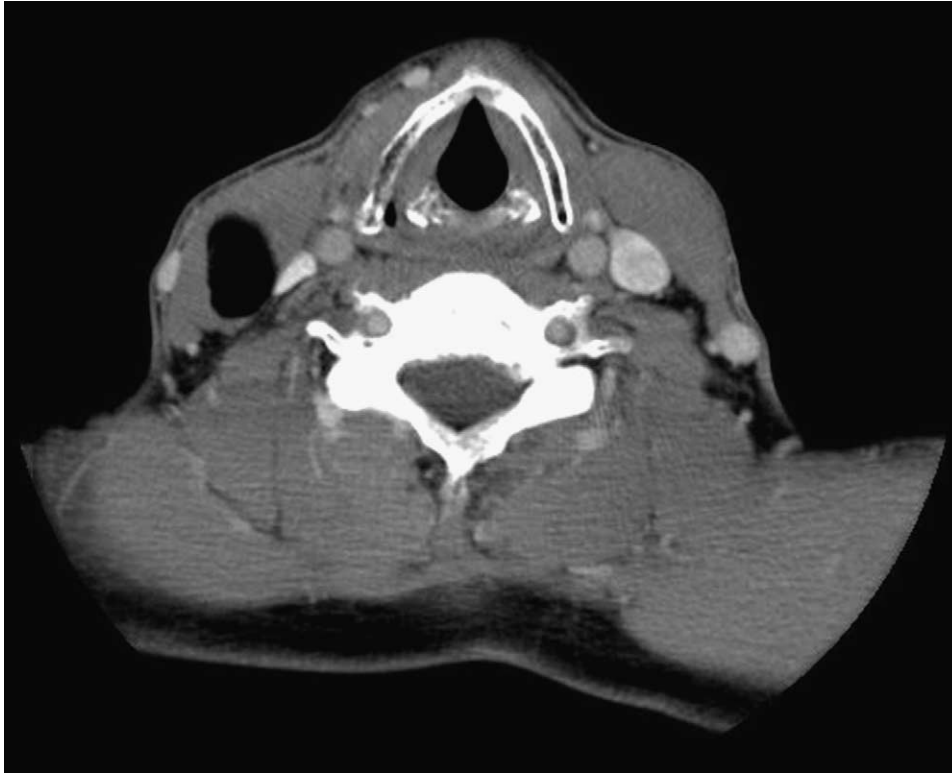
Axial CT scan of the neck showing a well-defined non-enhancing area of low attenuation within the right sternocleidomastoid muscle.
